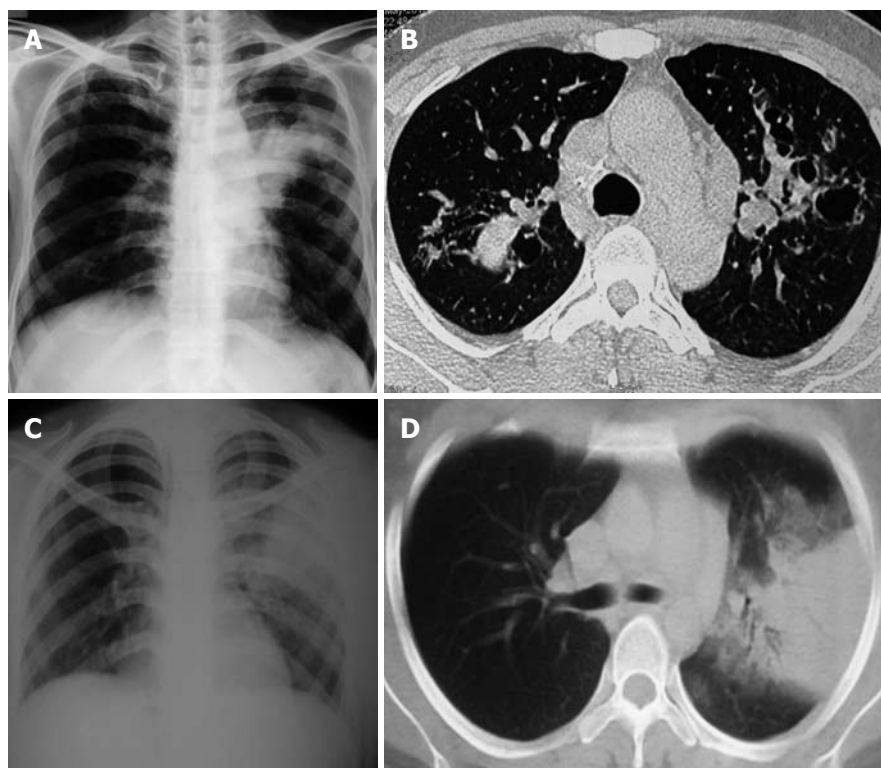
Chest radiograph. A, B: Chest radiograph (right panel) demonstrating consolidation in the left upper zone. Corresponding high resolution computed tomography of the chest (left panel) shows mucus-filled dilated bronchi; C, D: Chest radiograph (right panel) demonstrating consolidation in left upper zone. Computed tomography chest (left panel) shows typical consolidation with air bronchograms.
